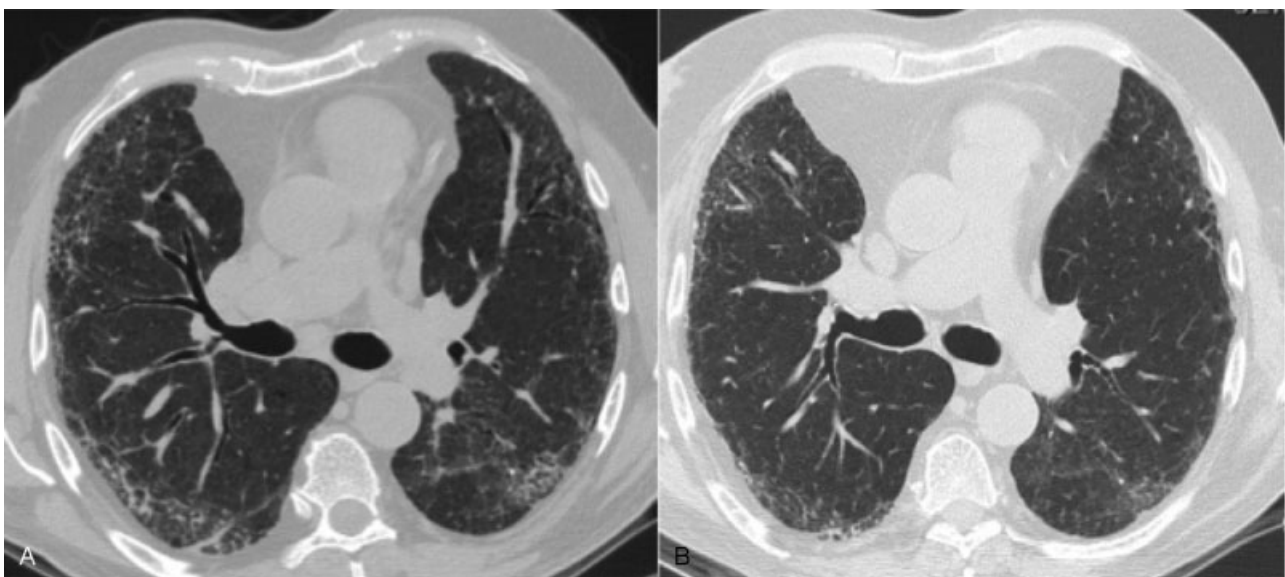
Evolution of a case idiopathic fibrotic NSIP, confirmed by lung cryobiopsy. (A) Baseline HRCT. Mild peripheral ground-glass attenuation is present in both lungs, with lower lobes prevalence. Subpleural sparing and bilateral dendriform calcifications are present as well. (B) Follow-up HRCT, after 4 years. Moderate reduction of ground-glass attenuation. Reticulation and traction bronchiectasis are substantially stable.
